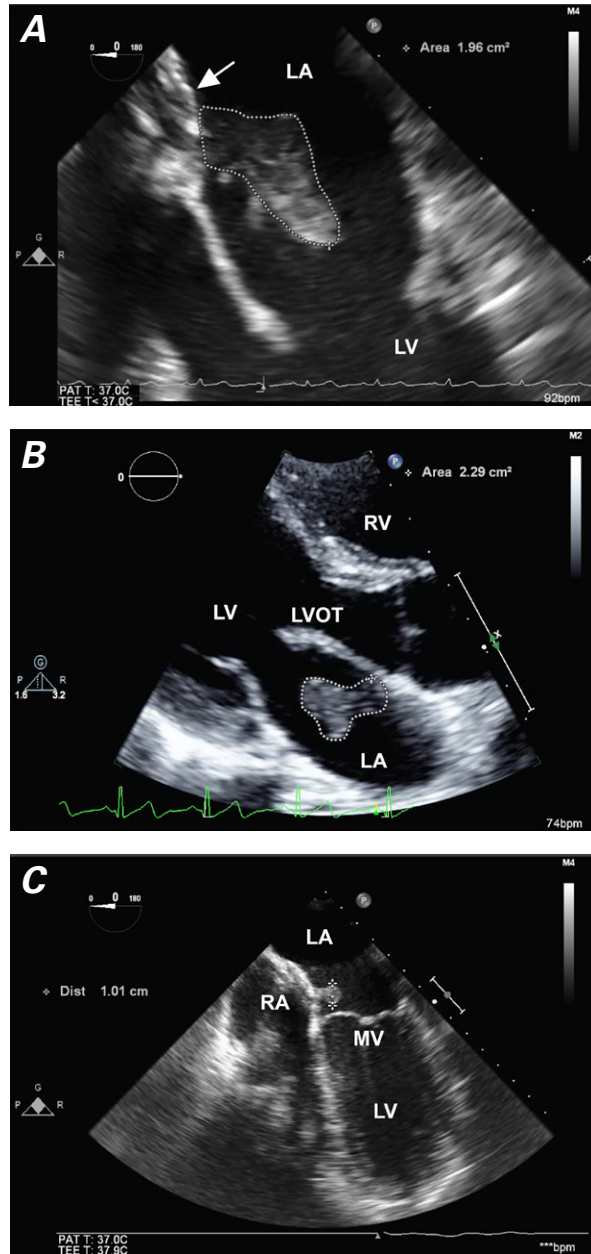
At presentation, a large vegetative mass (outlined) was seen on A) transesophageal and B) transthoracic echocardiograms. In A), the Amplatzer Septal Occluder (arrow) is shown. C) After 6 weeks of antibiotic therapy, a transesophageal echocardiogram shows a pedunculated mass remnant.
